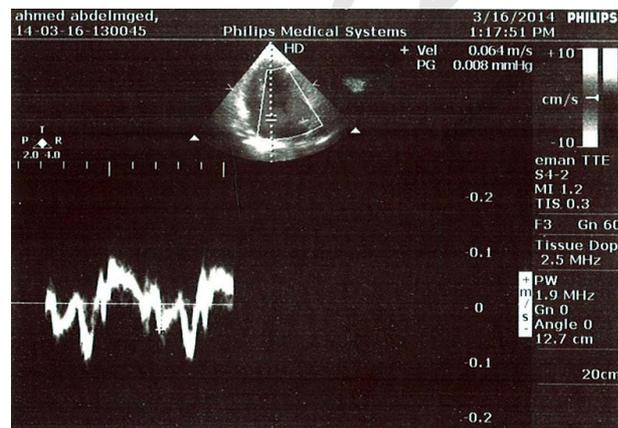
Tissue Doppler mitral annular velocity before dialysis.
